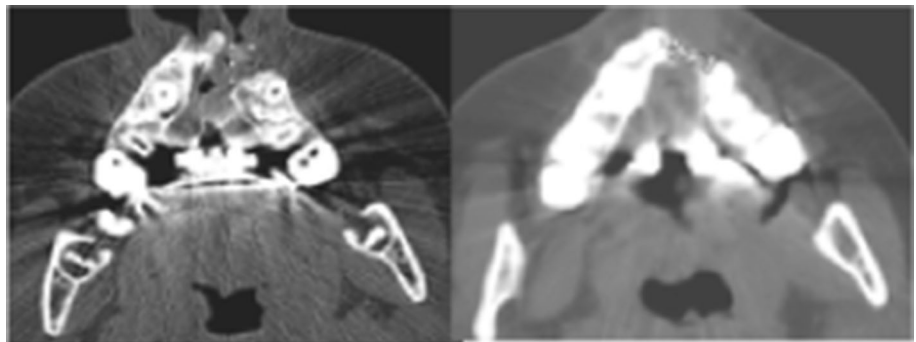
Preop and post-op CT evaluation of alveolar cleft defect
